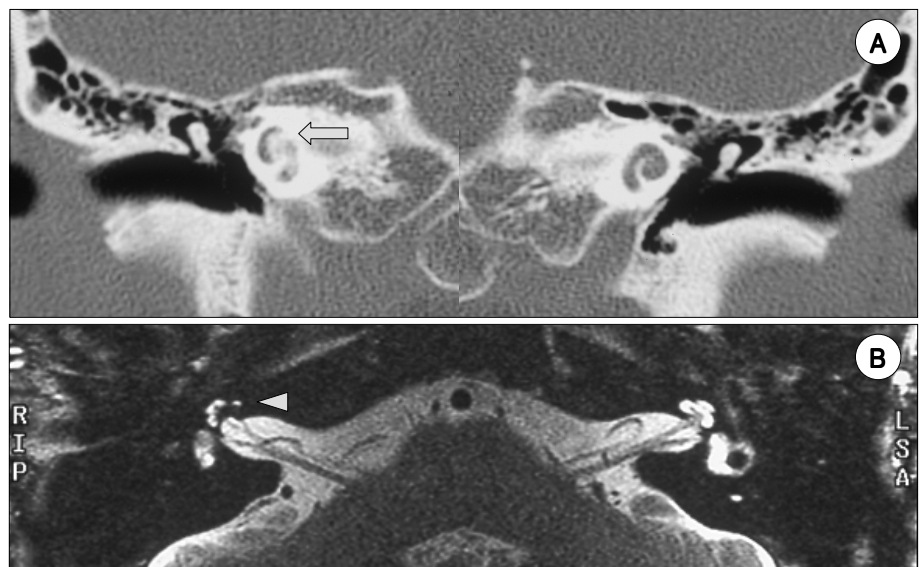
Axial temporal CT scan shows the right co-cochlear ossification (arrow) in the left cochlea (A). A partial obstruction by fibrotic tissue was noted after cochleostomy of the left cochlea. Temporal MRI reveals that the cochlear nerves are intact (B). A low signal density is noted in the right cochlea (arrow head).
